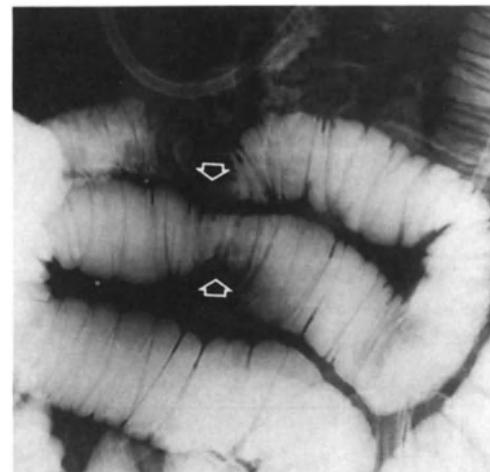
A Tight mechanical obstruction secondary to obstruction of afferent loop at neck of a femoral hernia (arrowhead). Although external abdominal hernias may be clinically reducible, the obstruction of a segment of the afferent loop at the neck may not preclude clinical reduction of the loops contained in the hernial sac. B Radiograph in lateral position after cessation of enteroclysis infusion in an obese patient with unexplained recurrent abdominal pain and distension. A small ventral hernia (arrow) is apparent during straining but reduces during quiet respiration. An abdominal CT showed adherence of bowel at incision site but the hernia was not shown with the patient in the supine position in suspended respiration.
